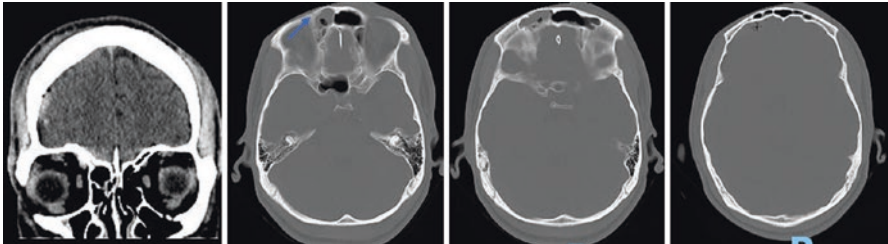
CT scan demonstrating a small subdural hematoma and pneumocephalus resulting from a right frontal bone fracture (arrow)
